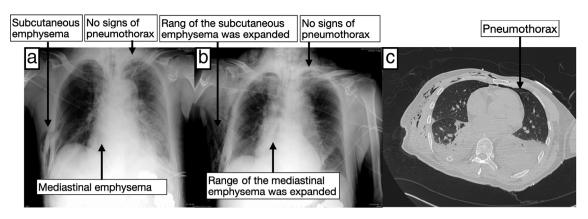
Chest X-ray and computed tomography (CT) scan of the patient. Chest X-ray showed no signs of pneumothorax both (a) on admission to ICU and (b) on the second day after surgery. (c) A CT scan verified the existence of a low volume left pneumothorax.
